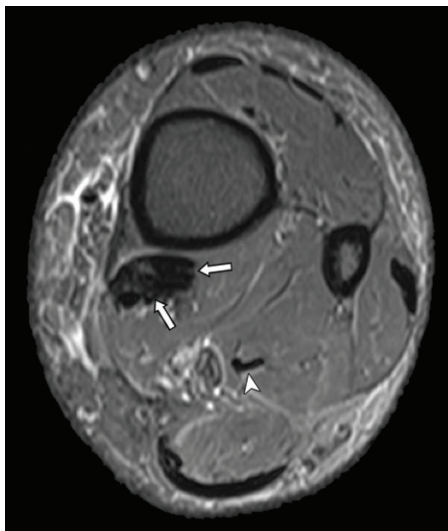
Tendon transfer for PTT insufficiency in a 54-year-old woman with Stage II AAFD after side-to-side fixation of the flexor digitorum longus and posterior tibialis tendons. Axial fat-suppressed proton-density-weighted MR image shows a markedly thickened tendon at their confluence (arrows). This normal post-operative appearance should not be confused with tendinosis and tearing of the PTT. Note the normal flexor hallucis longus tendon (arrowhead) located posterolateral to the reconstruction. Complications of tendon transfer include excessive tension at the reconstruction and a weakened heel rise.
